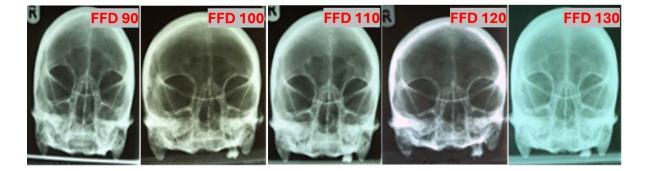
The radiographs of the skull at FFDs 90-130cm
